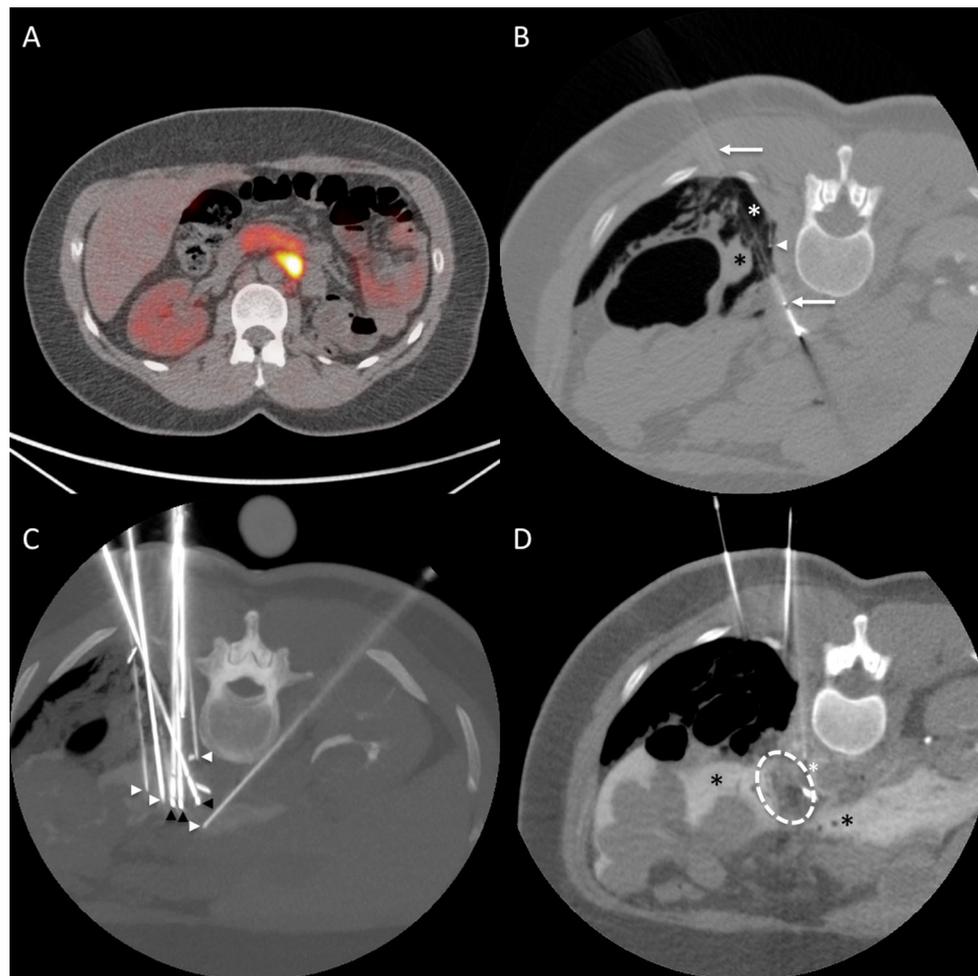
Cryoablation of a solitary retroperitoneal metastasis from malignant pheochromocytoma. A Axial PET-CT shows an avid metastasis located close to the aorta, pancreas and small bowel. B Carbodissection (white asterisk) is performed through a 22G spinal needle (arrowhead) to push away the colon (black asterisk) and create a safe pathway for cryoprobe insertion (arrow). C In total, 3
